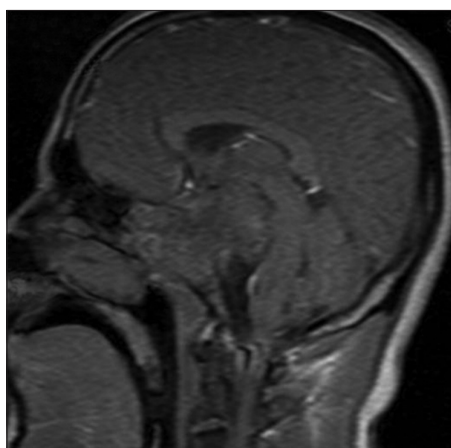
T1 MRI imaging showing clival lesion, osseous destruction and brain stem displacement
